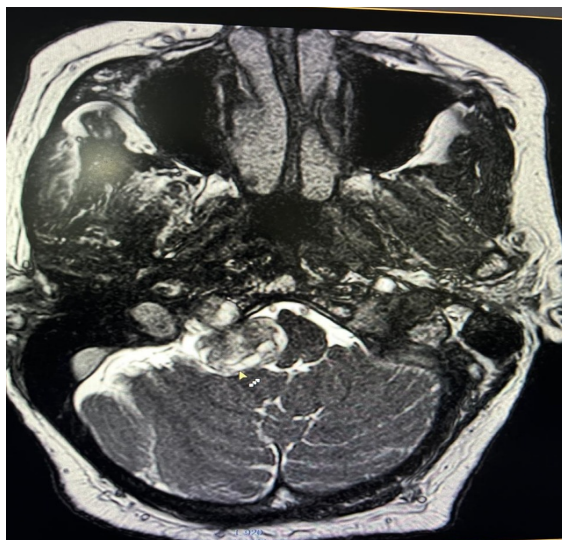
Axial T2-weighted MRI demonstrating a right cerebellopontine angle lesion extending into the internal auditory canal, suggestive of a vestibular schwannoma.
